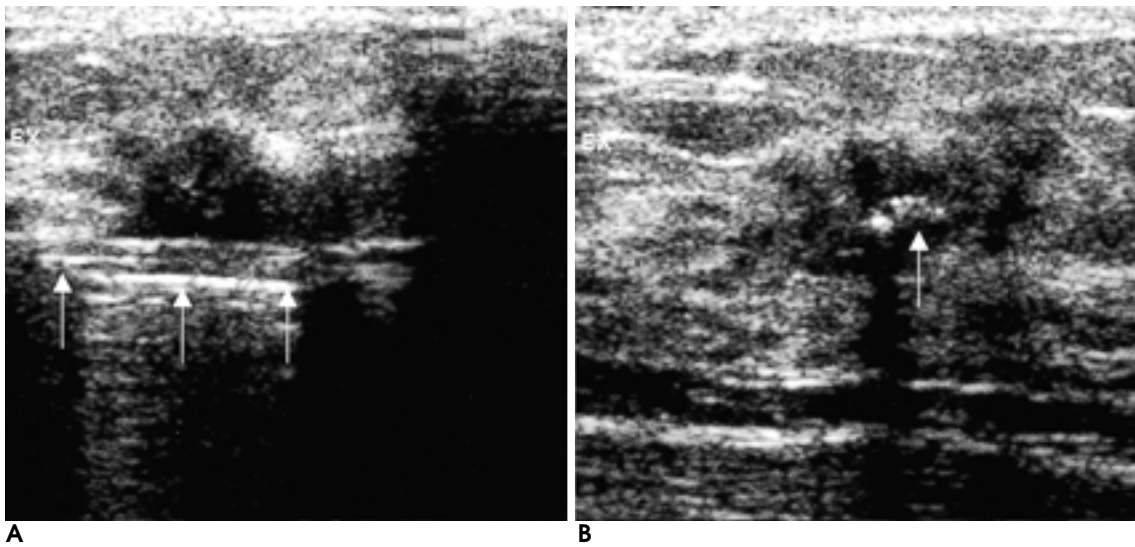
Invasive ductal carcinoma in a 33-year-old woman with palpable nodule in her left breast. Ultrasonography shows a $1.3 \times 1.1 \times 0.8$ cm irregular ill-defined hypoechoic mass at 11 o'clock area of her left breast. Transverse (A) and longitudinal (B) ultrasonographic scan shows mammotome needle (arrows) in posterior portion of the mass.
